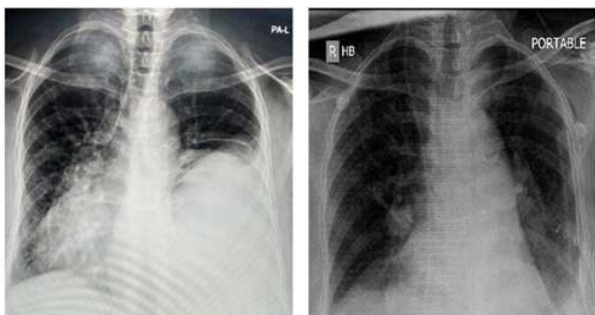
Preoperative Chest Radiograph Showing a Large Homogenous Opacity, Postoperative Chest Radiograph Demonstrating Complete Expansion of Lung
